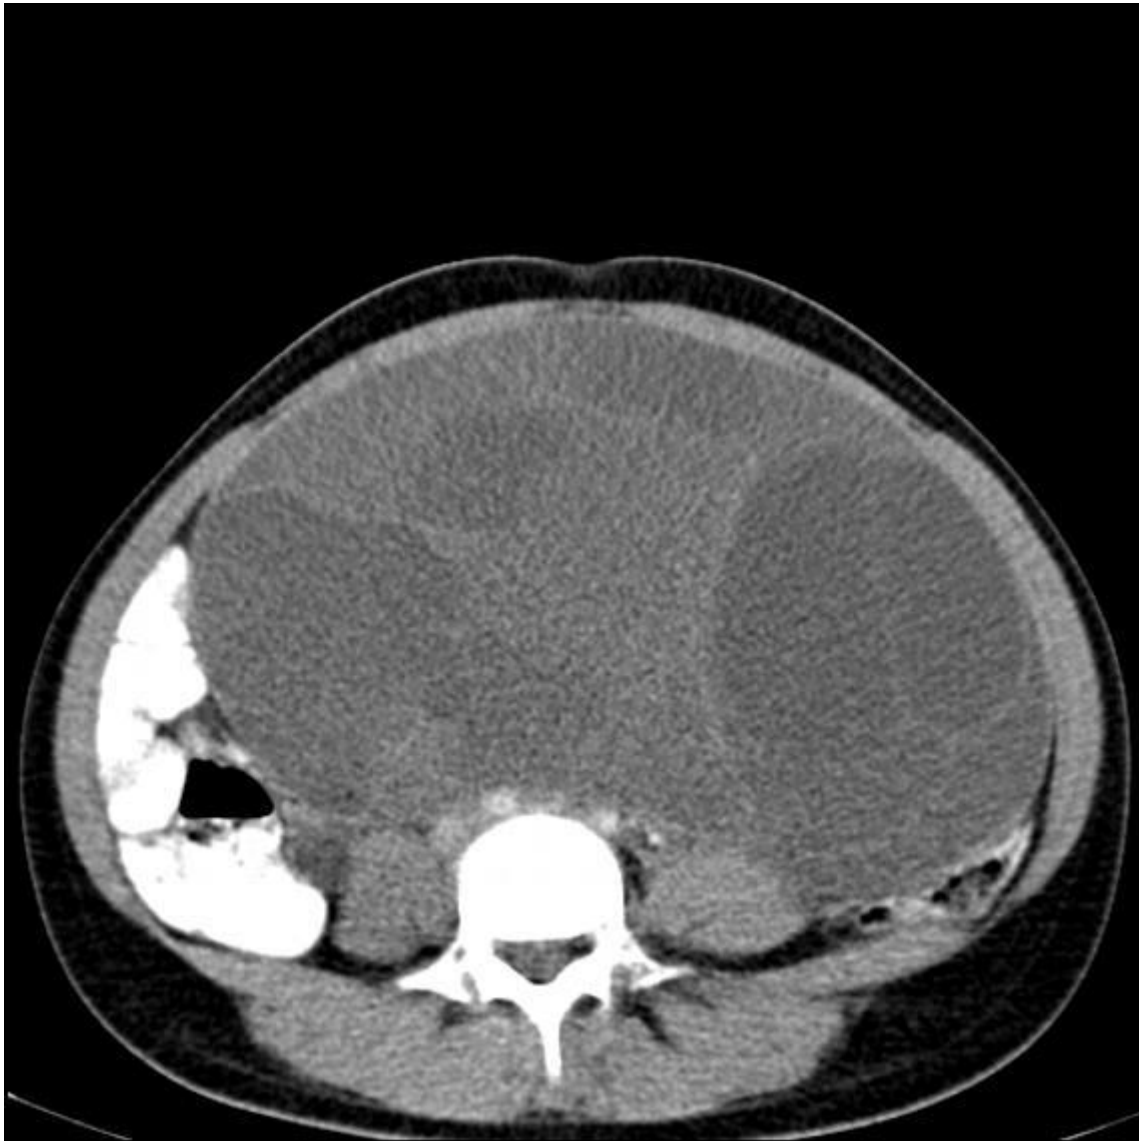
An enormous mass occupying almost the entire abdomen on CT.
